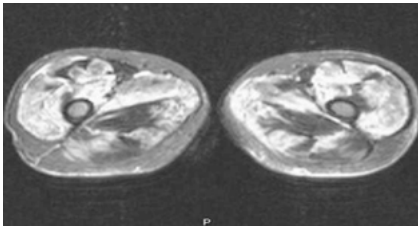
MRI scan of the proximal thighs of a patient with juvenile dermatomyositis showing patchy areas of bright signal through the muscles indicating the presence of extensive myositis.
